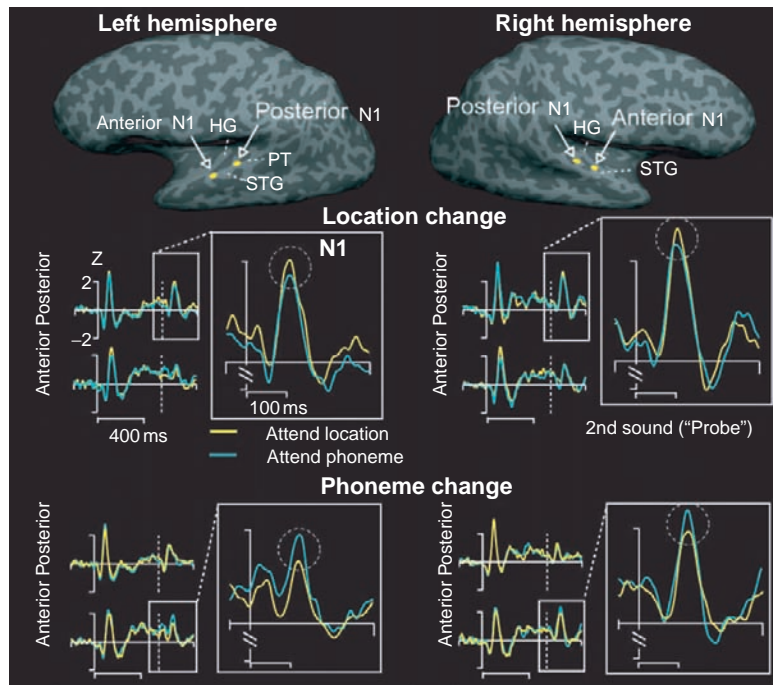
(Top) MEG locations of equivalent-current dipoles (ECD) sources to two different words, “Adaptor” and “Probe,” sequentially spoken from different external spatial locations, displayed on the inflated brain hemispheres, MRI images, of one subject. (Middle and bottom) Amplitude-normalized source waveforms in the middle indicate that the “where” pathways are associated with the N1 locations, whereas waveforms at the bottom for parallel “what” pathways are connected with the N1 locations. Differences (peak changes encircled) in the averaged waveforms indicate the effects of selective attention to either sound or location. The N1 response amplitudes to Probes (encircled) are modulated task-dependently. The posterior N1 activity to Probes following spatially different Adaptors is enhanced by spatial attention. The anterior N1 activity to Probes following phonetically different Adaptors is enhanced by phonetic attention. *From [1].*
